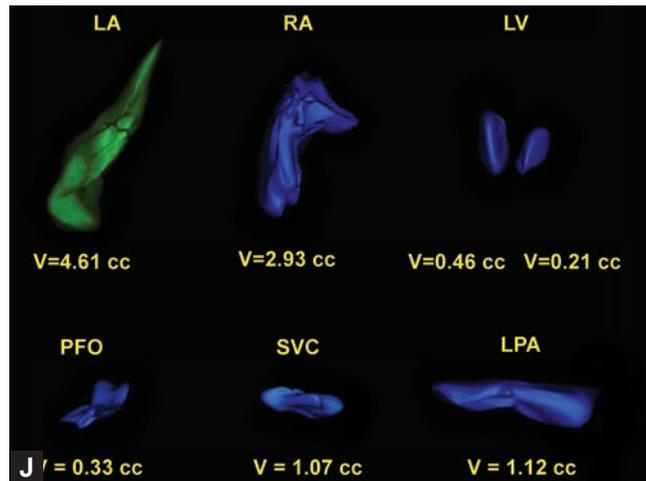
to C: Two-dimensional transesophageal echocardiography of a thrombus in transit through a patent foramen ovale. (A) Arrows show a mass in the right atrium (RA) and multiple masses in the left atrium (LA). The tricuspid valve (TV), right ventricle (RV), mitral valve (MV) and left ventricle (LV) are also seen. (B) Arrow shows point where mass is stretching open patent foramen ovale when transiting from the RA to the LA. The superior vena cava (SVC) is also seen. (C) Arrow shows the mass within the left pulmonary artery (LPA).
